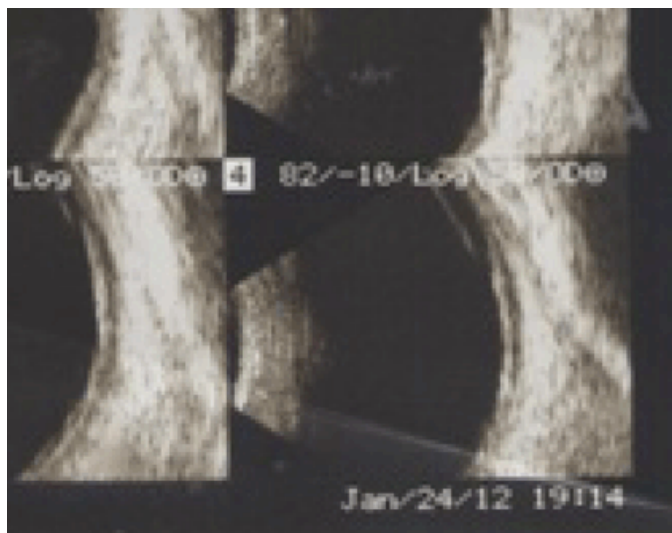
Ultrasonography B-scan of left eye showing exudative retinal detachment.
